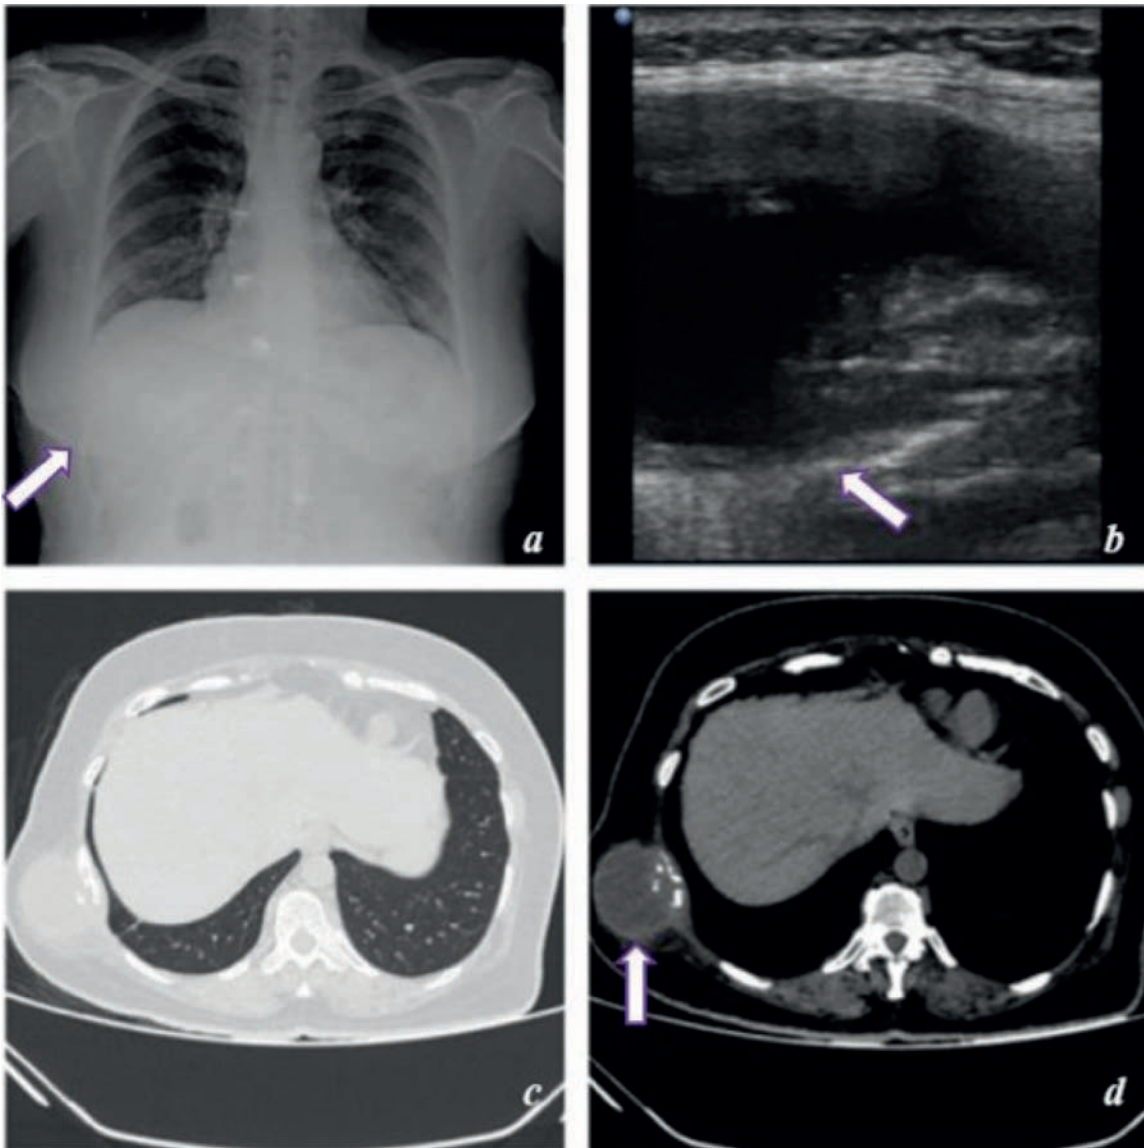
Chest radiography shows focal soft tissue opacity at right lower costal margin / lateral chest wall over the 9th rib area with likely bony erosion. Chest ultrasonography shows a hypoechoic fluid lesion with dense echoes at right lower lateral chest wall.
